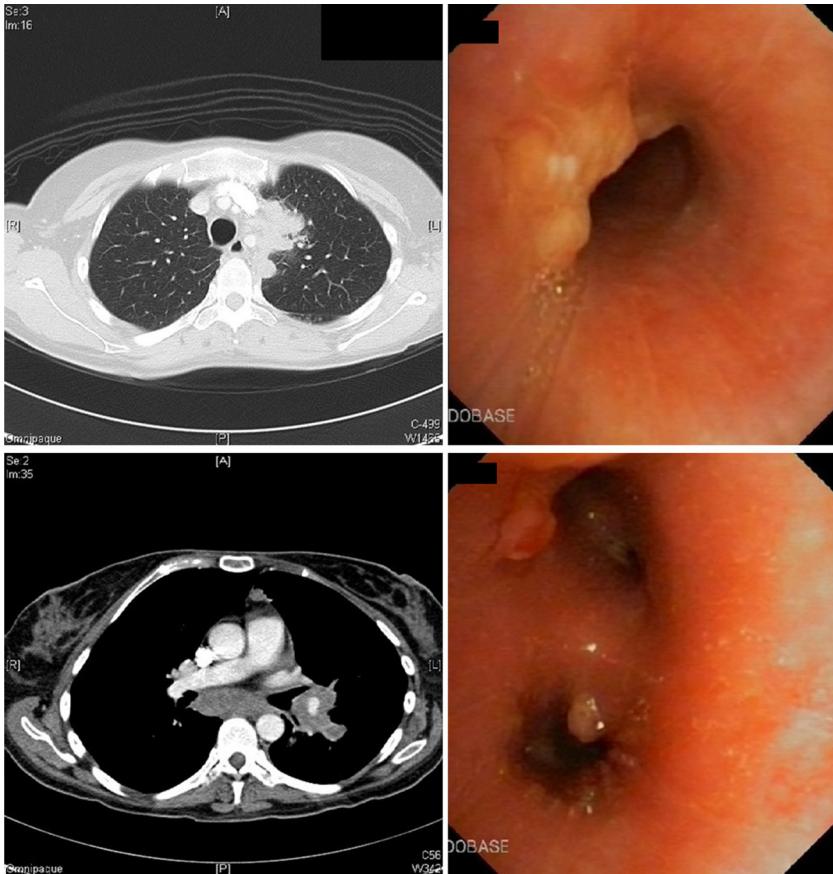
Bronchoscopy and CT images before treatment.
